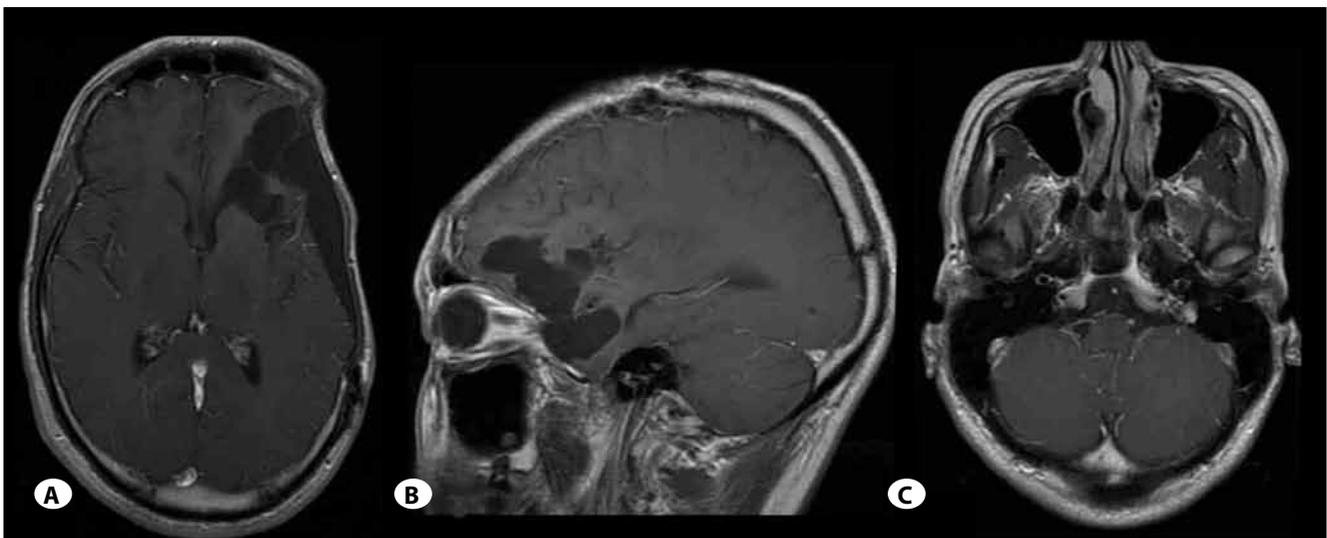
Periodical follow-up MRI portrayal with Gd enhance indicates no residual tumor during maintenance therapy for anaplastic astrocytoma (A; axial, b; sagittal). (B, C) There was no mass in the posterior fossa during maintenance therapy for anaplastic astrocytoma.
